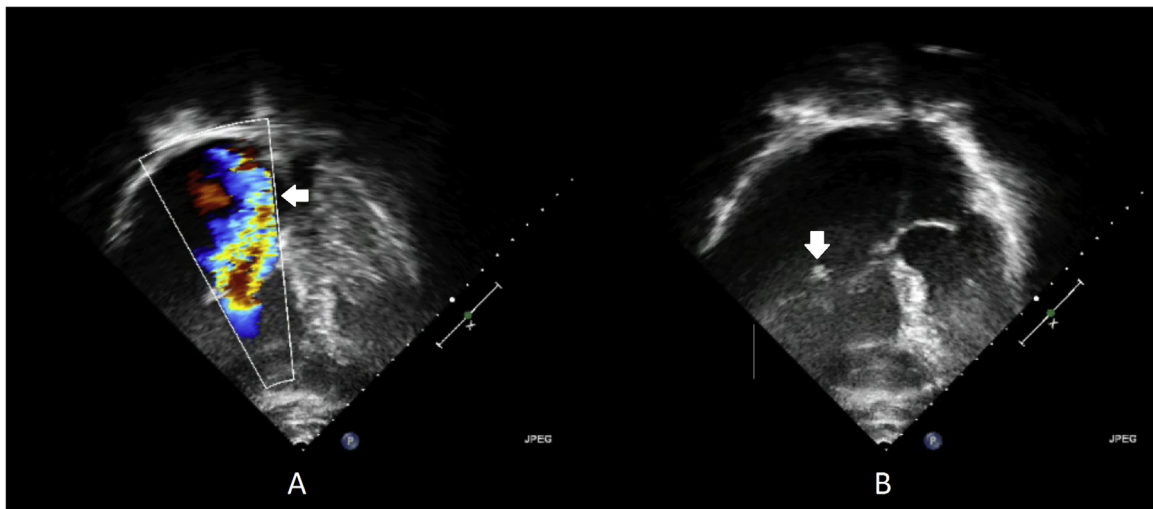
A) Preoperative echocardiography with color Doppler showing severe tricuspid insufficiency (arrow); B) Preoperative echocardiography showing ruptured chordae tendineae (arrow).
